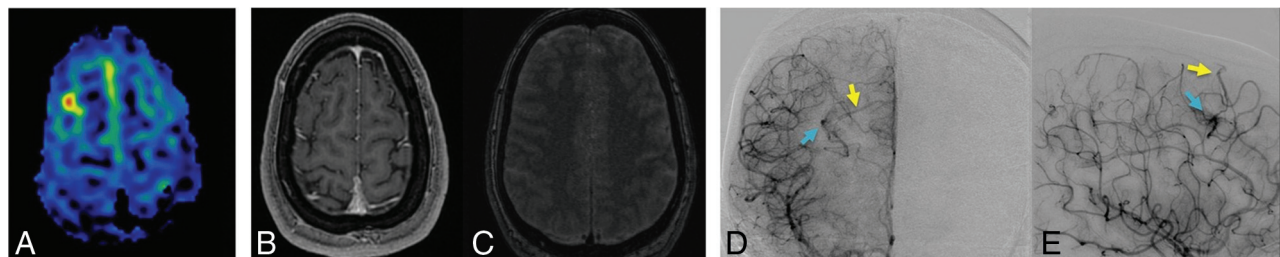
Adult patient with genetically confirmed HHT and mild epistaxis, presenting for a screening brain MR imaging and MRA. A, Postprocessed ASL image with a focus of increased signal along the right superior frontal gyrus. B and C, Postgadolinium 3D BRAVO (3D brain volume) and non-contrast time-of-flight MRA, respectively, with no corresponding vascular abnormality demonstrated on these conventional MR imaging sequences. Frontal (D) and lateral (E) DSA images acquired from a selective right ICA injection in the late arterial phase demonstrating an ill-defined compact 12-mm AVM nidus (blue arrows) associated with early filling of a superficial cortical vein (yellow arrows) along the right superior frontal gyrus draining into the superior sagittal sinus.
